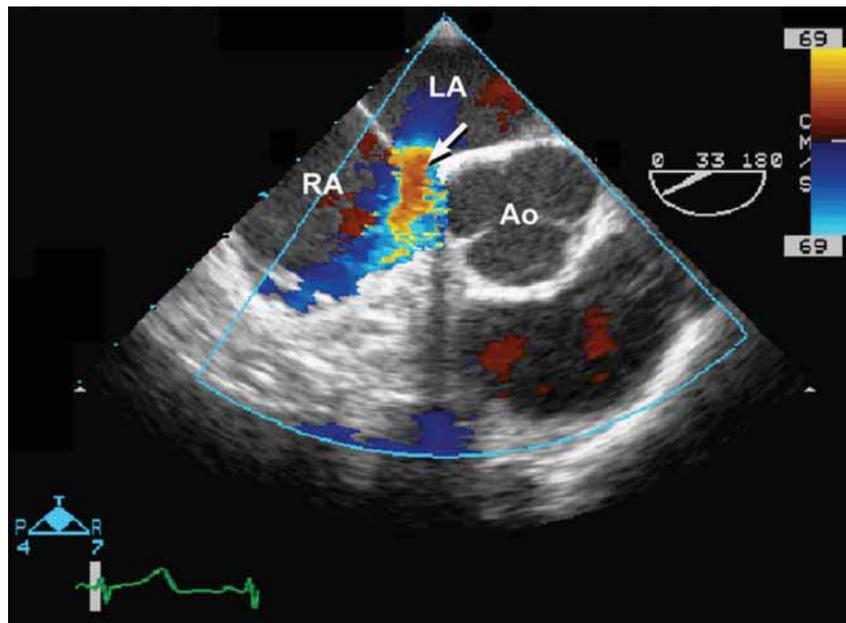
Midesophageal view of the interatrial septum with color Doppler applied shows left-to-right shunt via a secundum atrial septal defect. (Please see companion DVD for corresponding video.)
